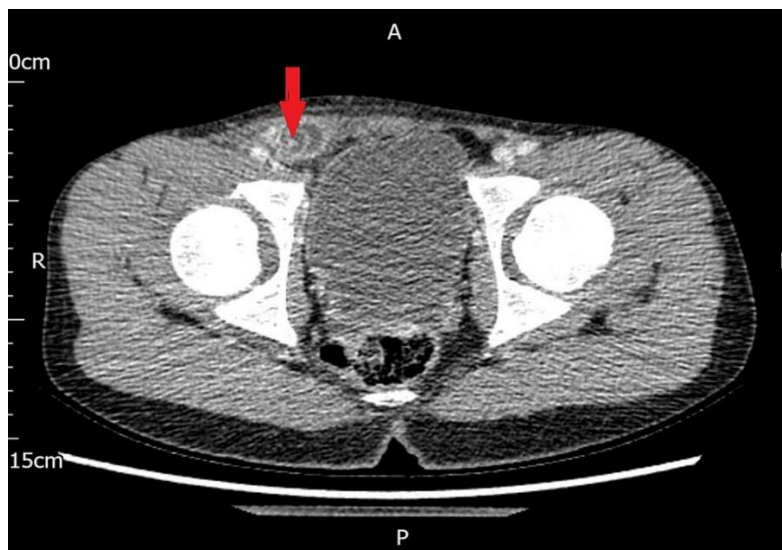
Axial CT image showing the right inguinal hernia, which contained the appendix.
